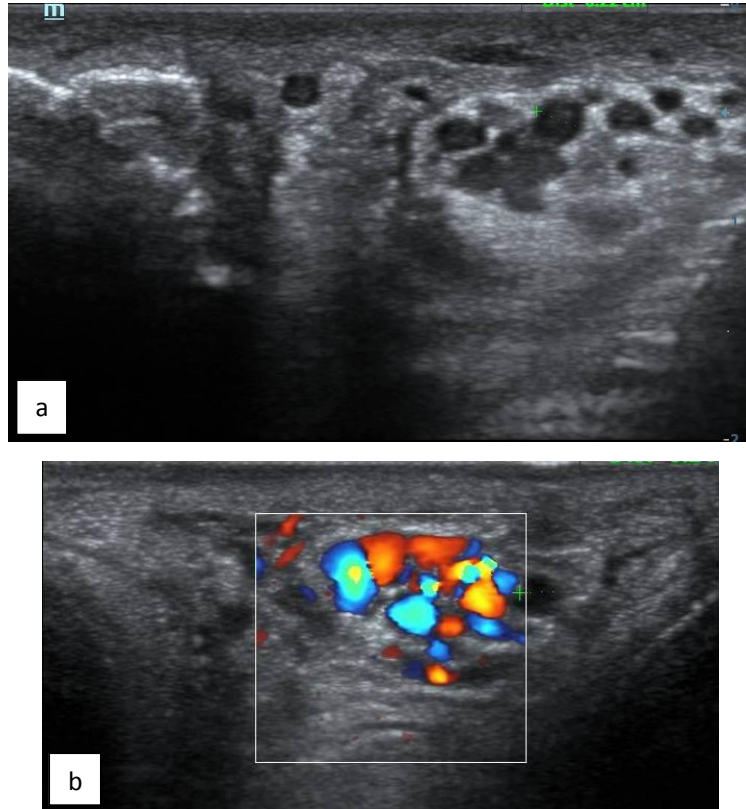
Varicocele demonstrated in (a) Grayscale and (b) Color Doppler
